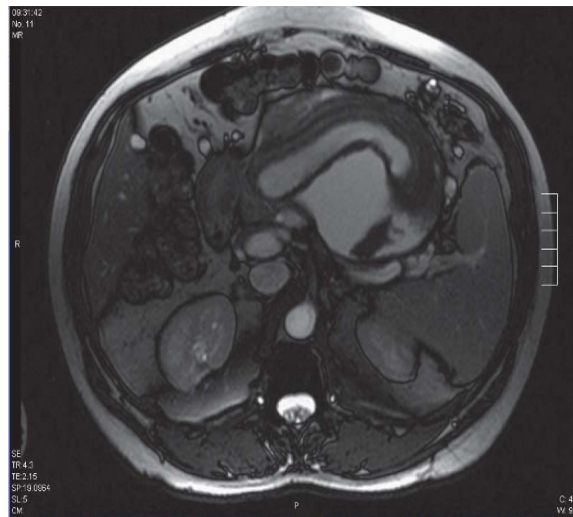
MRI abdomen on the first presentation showing the cyst.
